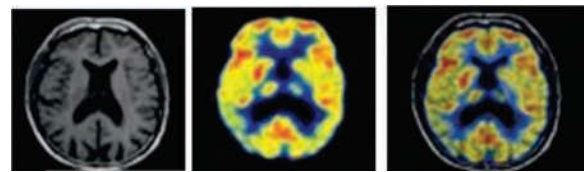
Multi-modal registration of brain images. Image on the left side is brain MRI while the image in center is PET image of the same patient. Image on the right side is the registered PET image with MRI image
